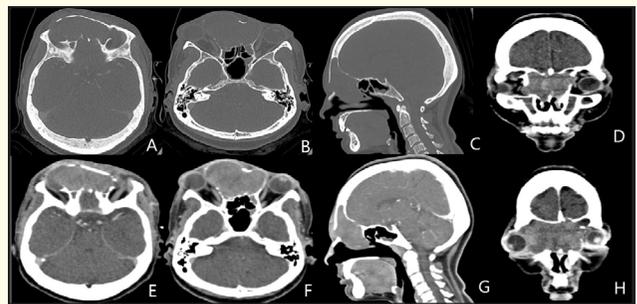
Preoperative plain CT PNS (A/B/C): destruction of anteroinferior and posteroinferior wall with floor of frontal sinus with destruction of right lamina papyracea. Preoperative contrast CT PNS (D-H): Mildly enhancing mass arising from frontal sinus extending into anterior ethmoids, sphenoid sinus and right orbit with suspected intracranial extension parallel to cribriform plate.
